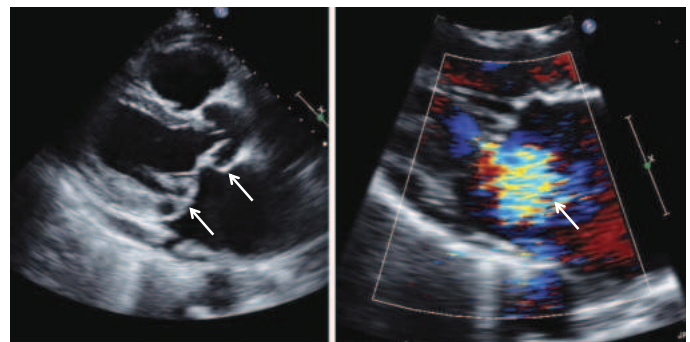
Barlow's valve with classic mitral valve prolapse, as seen on transthoracic echocardiogram in parasternal long-axis windows. Left: parasternal long-axis window, showing both myxomatous leaflets (arrows) billowing into the left atrium in late systole. Right: same window with color Doppler showing significant mitral regurgitation (arrow) in systole. (Courtesy of Justina Wu, MD, PhD.)
